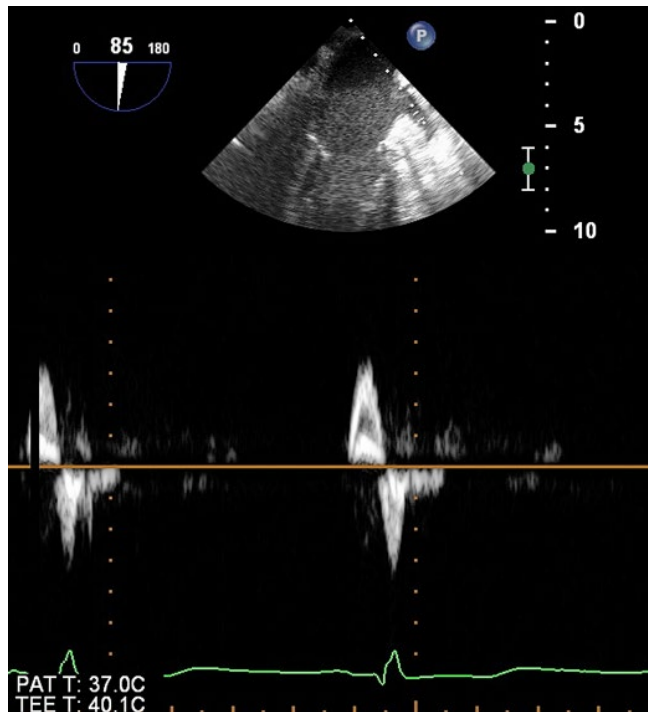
TOE view shown in Figure 6.7 with pulsed-wave Doppler trace of temporally limited (to systole) bidirectional flow in the left atrial appendage.
